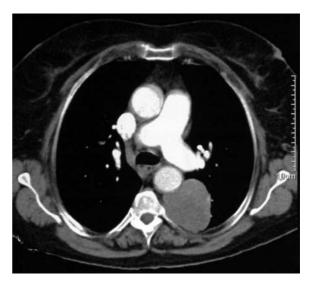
CT-thorax: locally advanced lung tumor, with infiltration into the thoracic aorta and the thoracic wall suspected.
